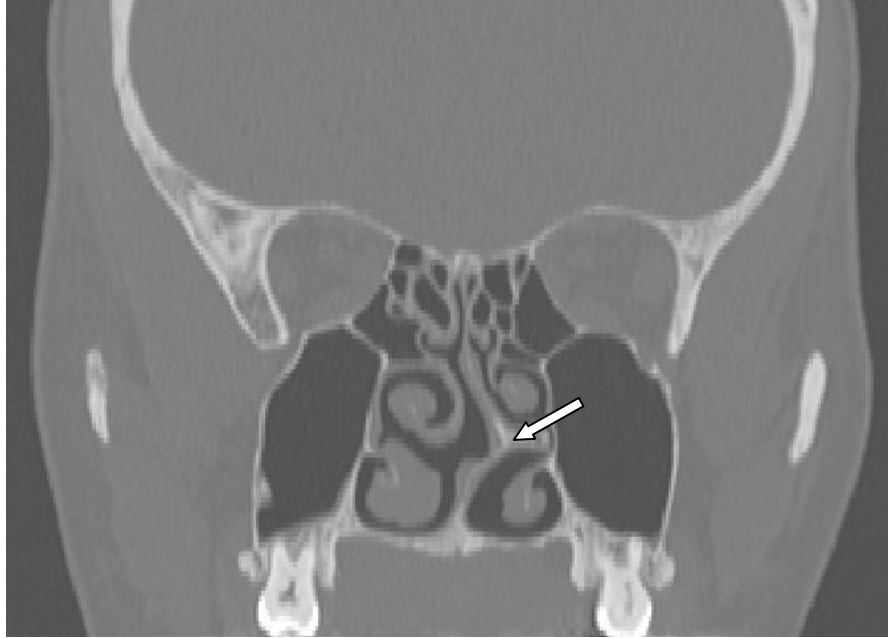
Coronal view from a computed tomography scan of a patient with a deviated nasal septum. The septal deviation causes the septum to be in contact with the lateral nasal wall
